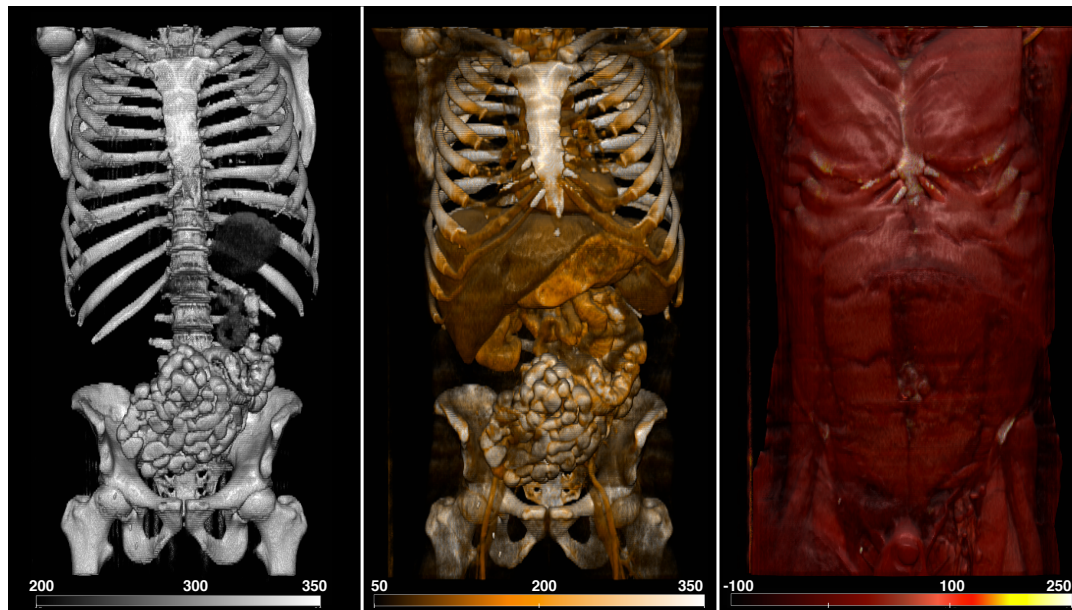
A 3D rendering of anatomies reconstructed from the CT scan shown in Fig. 2.2. The skeletal system (left), inner organs and surrounding bones (middle), and musculature (right) are obtained by restricting the range of Hounsfield values in the CT scan. It can be also seen that the HU values of different organs overlap partially.
